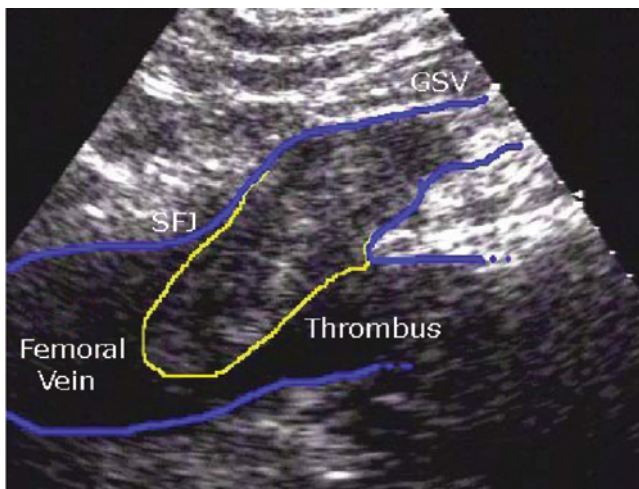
Early post treatment duplex scanning should be performed. Evidence of a protruding thrombus from the saphenous vein into the femoral vein should be looked for. (Adapted from Pichot O, *Atlas of Ultrasound Images*, Copyright VNUS® Closure)
